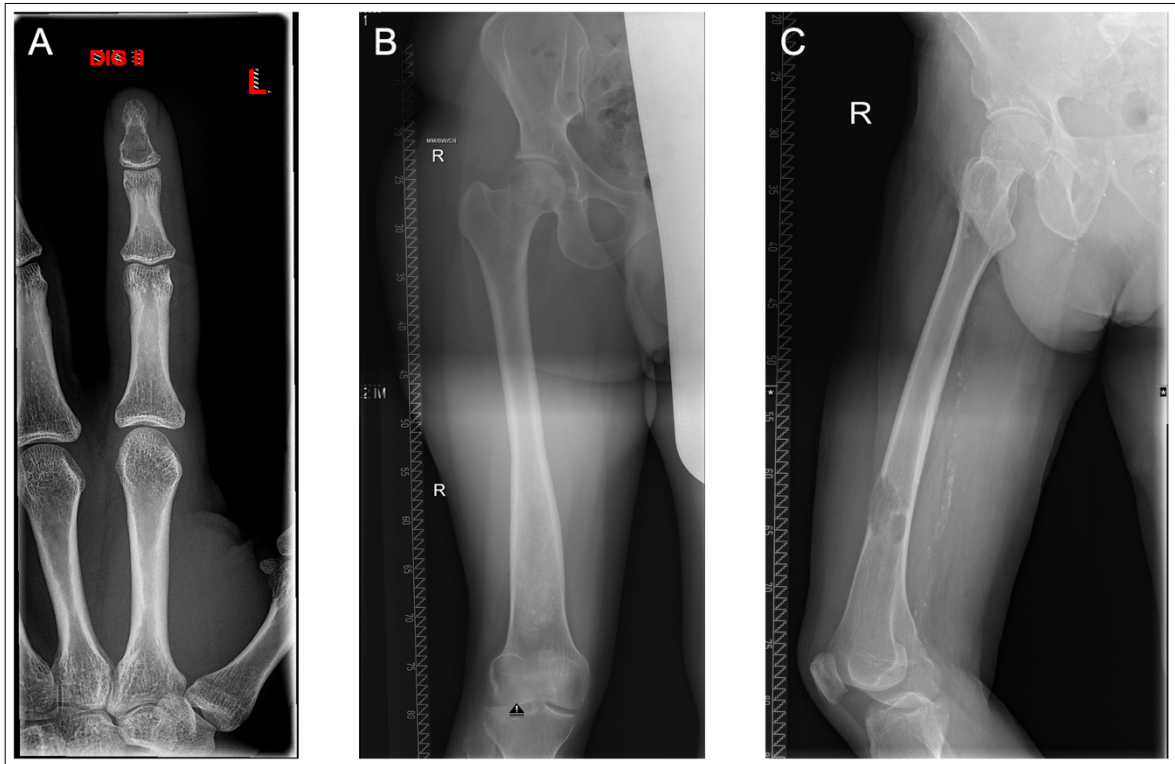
X-ray images of different chondromatous tumours at different locations. (A): Enchondroma of the distal phalanx of digitus II (male, 26 years). (B): ACT of the distal femur (male, 27 years). (C): Dedifferentiated chondrosarcoma of the distal femur (male, 81 years).
